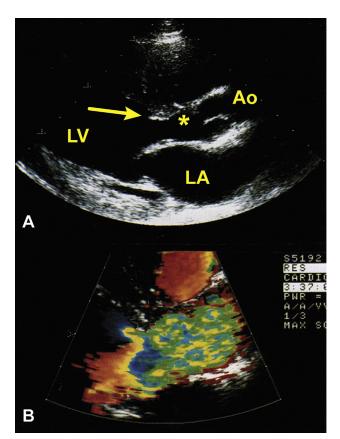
Long-axis echocardiographic images. (A) The arrow points to the insertion site of a false tendon. The asterisk indicates the site of prior membrane resection. (B) Note the large cloud of turbulence originating at the site of attachment of the false tendon, which fills the subaortic region. The turbulent cloud comes into contact with the site of prior membrane resection (asterisk) and may therefore represent a potential stimulus for membrane recurrence. Ao, Aorta; LA, left atrium. Reproduced with permission from Gewillig et al. 45
